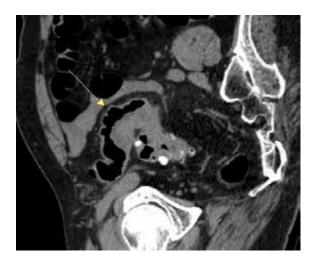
CT colonography shows asymmetrical thickening of sigmoid colonic wall (arrow) in chronic diverticulitis, resembled cancer.
